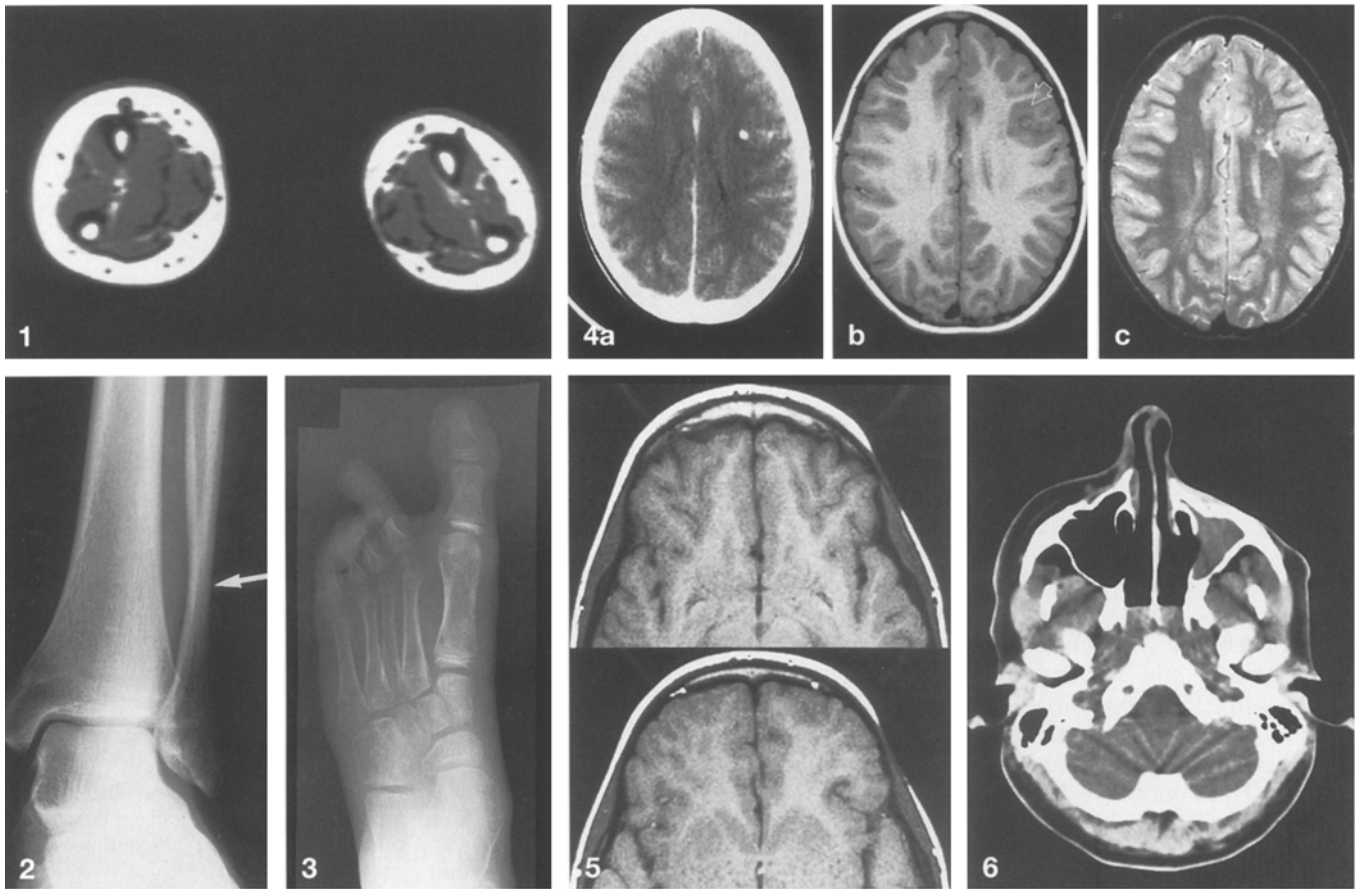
A 14-year-old boy with a 3-year history of involvement of the left forearm. Axial T1-weighted image (TR 500/TE 11) reveals marked atrophy of the subcutaneous tissues and muscles of the left forearm
